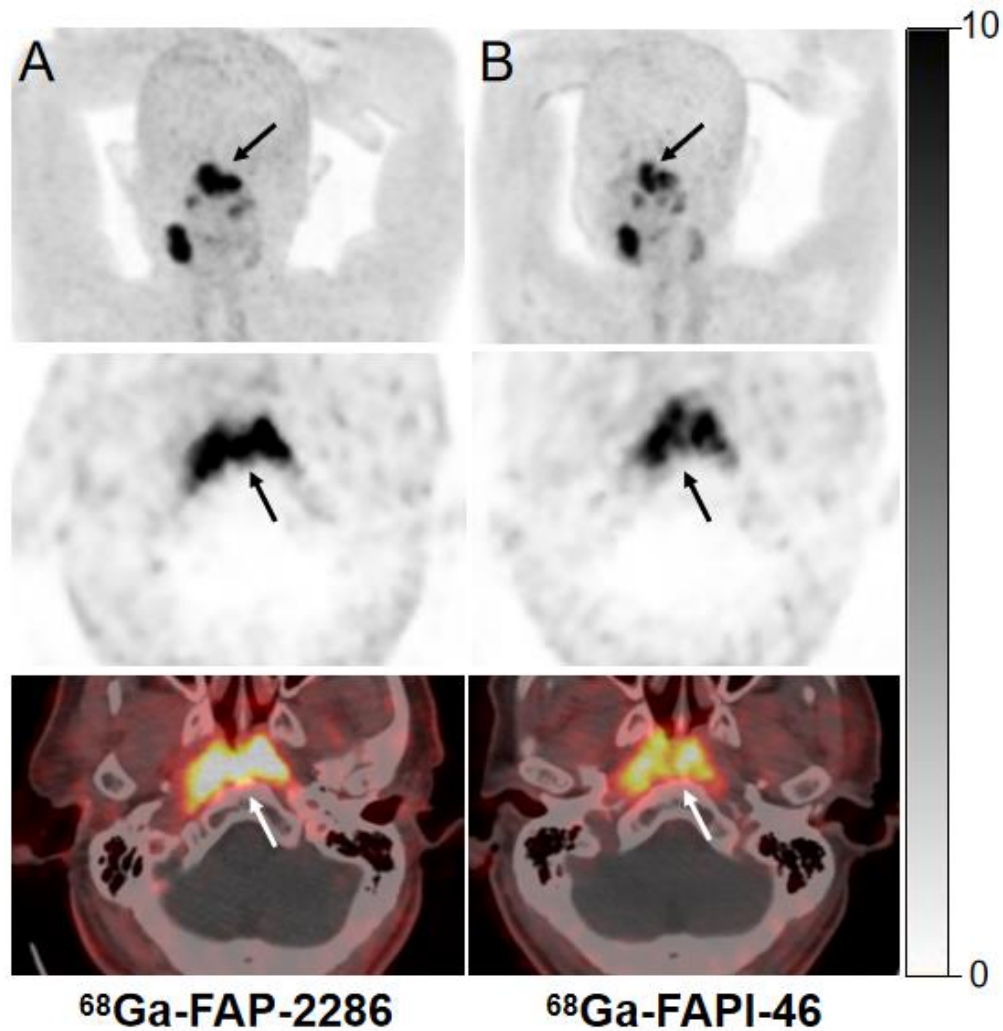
A 72-year-old man with newly diagnosed nasopharyngeal carcinoma underwent PET/CT for tumor staging. ^{68}Ga -FAP-2286 PET/CT (A) showed higher radiotracer uptake in the primary tumor (SUVmax, 17.4 vs. 12.2, arrows) than ^{68}Ga -FAPI-46 (B).
